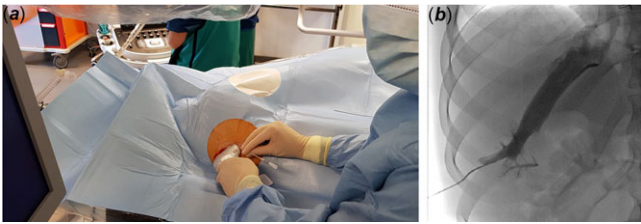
Ultrasound-guided puncture below the right costal margin, between the midclavicular and right anterior axillary line (at a 30° to 40° angle) directing the needle superiorly, posteriorly, and medially towards the patient's left shoulder (a). Angiographic verification of the transhepatic access before sheath introduction (b).
